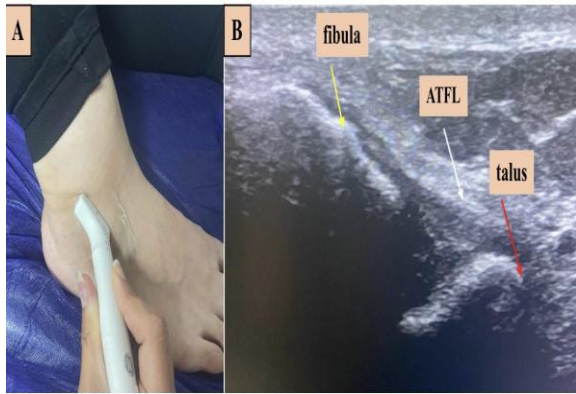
A) shows the position of the probe during the examination of the ATFL in cases of suspected tear, that is positioned in the transverse plane (parallel to the axis of the ligament), ventral to the lateral malleolus. B) ultrasound appearance of normal (intact) ATFL (white arrow).
